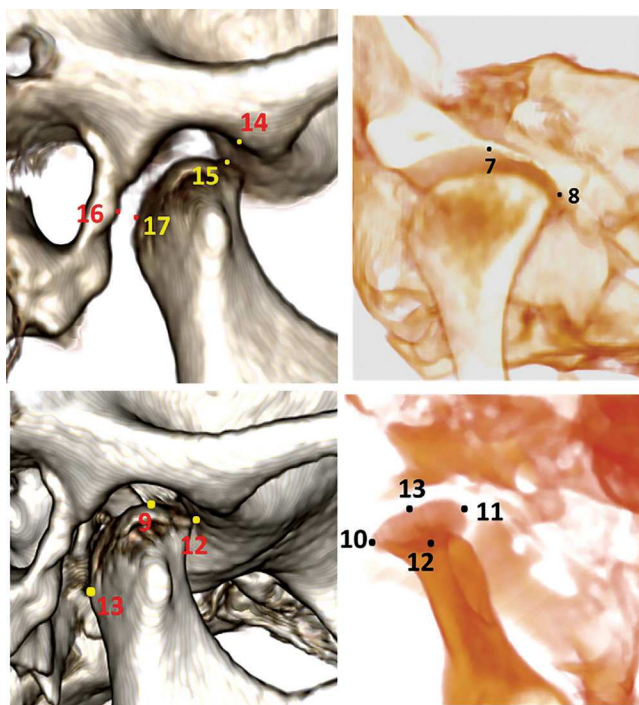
Image of the temporomandibular joint in cone-beam computed tomography. Source: Alhammadi et al.⁴, 2017.
